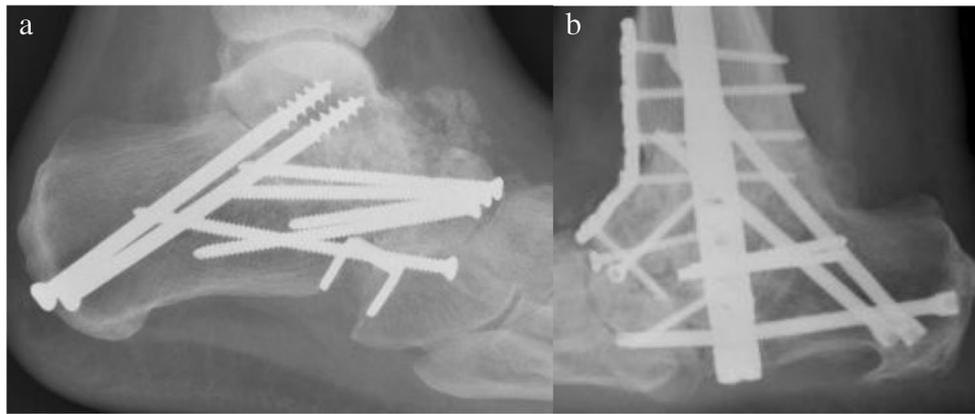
Radiographic findings of arthrodesis changes related to stages III and IV PTTD. a Lateral ankle radiograph in a 62-year-old woman with stage III PTTD demonstrates extensive hindfoot hardware, including multiple screws associated with a triple arthrodesis of the subtalar, talonavicular, and calcaneocuboid joints. b Lateral ankle radiograph in a
